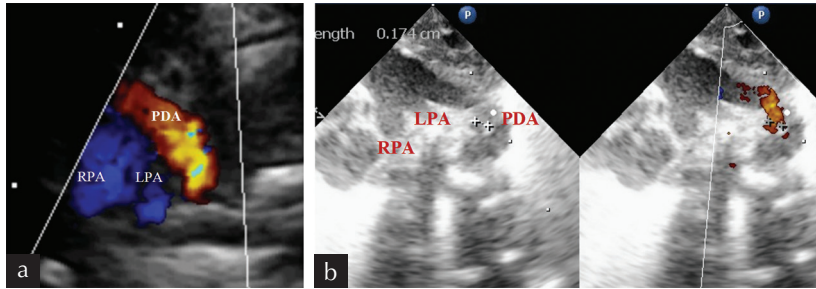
Echocardiographic diagnosis of a PDA on the ductal view ('three-legged stool' appearance)
